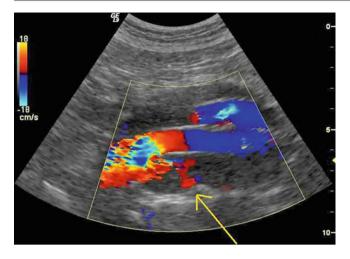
Color Doppler image showing a Type II endoleak with reversed flow through a posterior lumbar branch (*arrow*)
